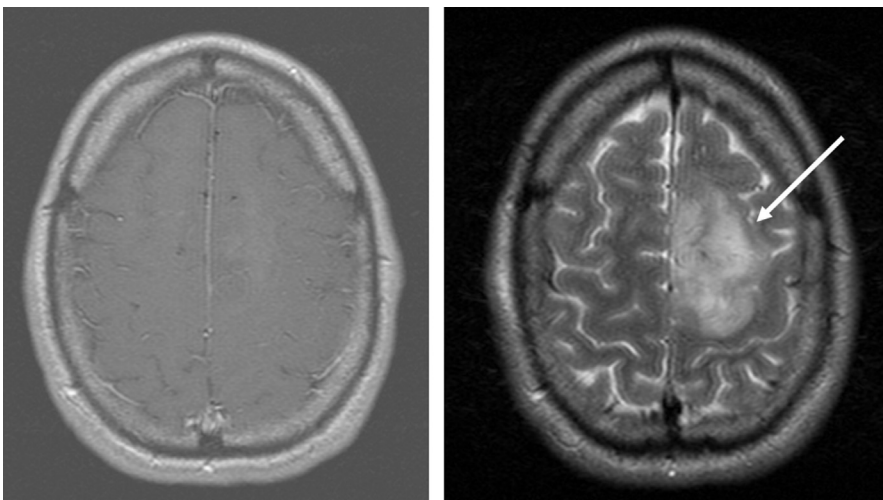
Example of LGG demonstrating a lack of contrast enhancement (*left*) but significant hyperintensity on FLAIR (*right*) and T2-weighted MRI sequences. Arrow indicates tumor in the posterior left frontal lobe.
